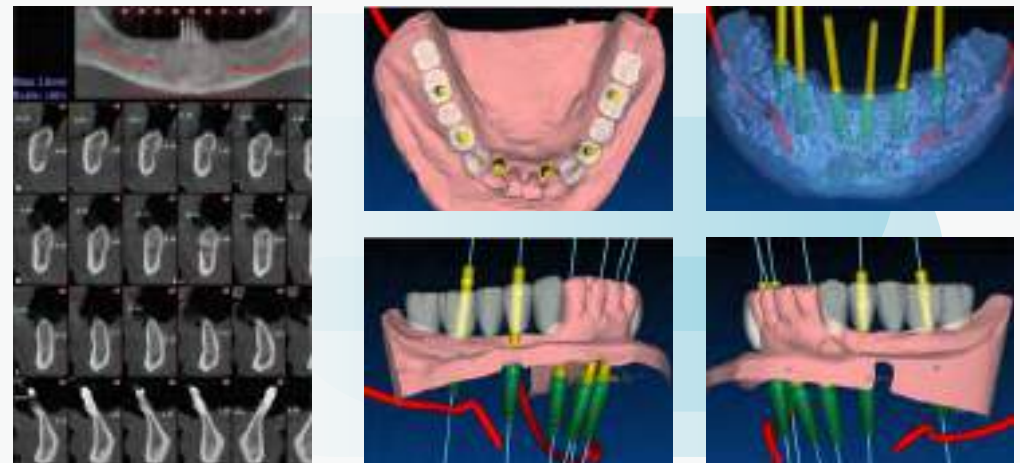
(3,4) Preliminary evaluation with cone beam computed tomography (CBCT); (5-8) Implant planning with a guided implant surgery software.
